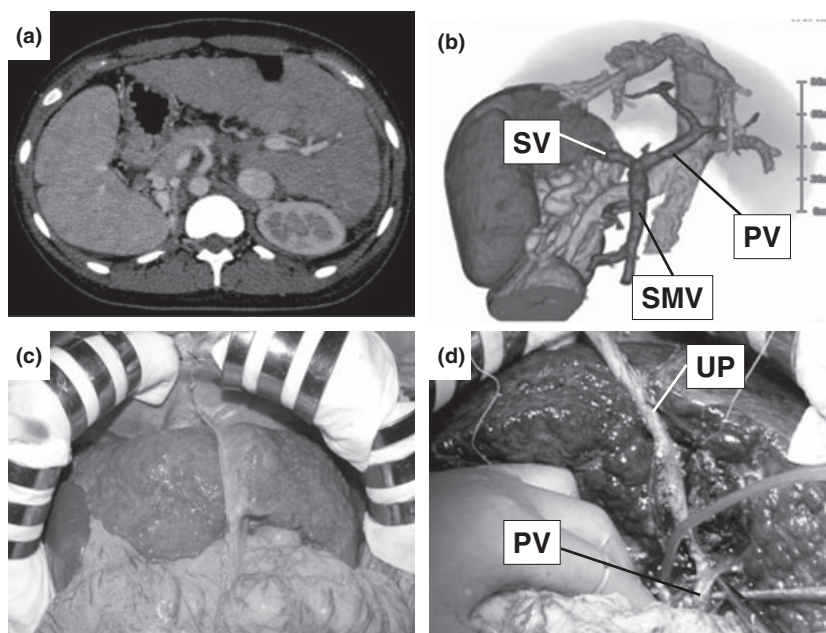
Preoperative imaging and operative findings of the recipient. (a) Abdominal CT scan. (b) Three-dimensional image of the portal vein and hepatic veins. (c) Intra-operative appearance of situs inversus with a cirrhotic liver. (d) The anatomical left portal vein is dissected high up to the umbilical portion to obtain a longer portal vein. SV, splenic vein; SMV, superior mesenteric vein; PV, portal vein; UP, umbilical portion of the portal vein.
